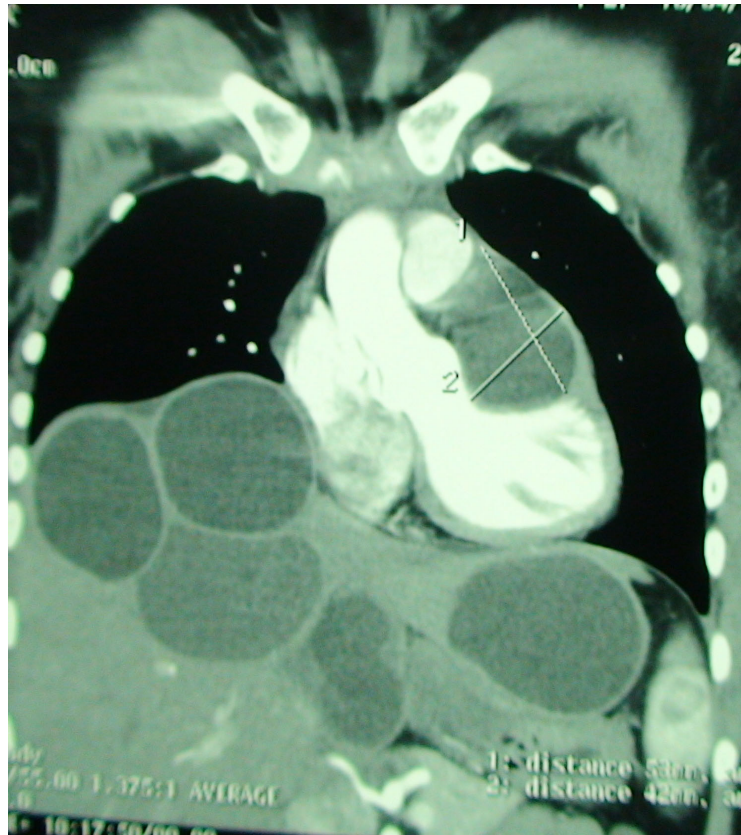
Computed tomography (CT) scan shows a large, single hydatid cyst in mediastinum and large multiple hydatid cyst in liver.
